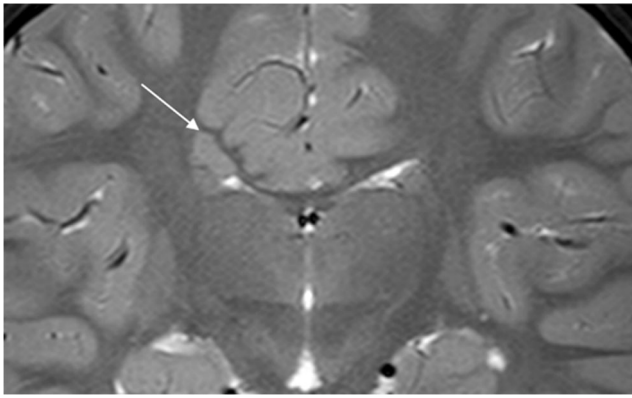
Case 1, a boy age 4 years 6 months. T2-weighted coronal MR brain image shows bilateral periventricular nodular heterotopia of gray matter (*arrow*)
